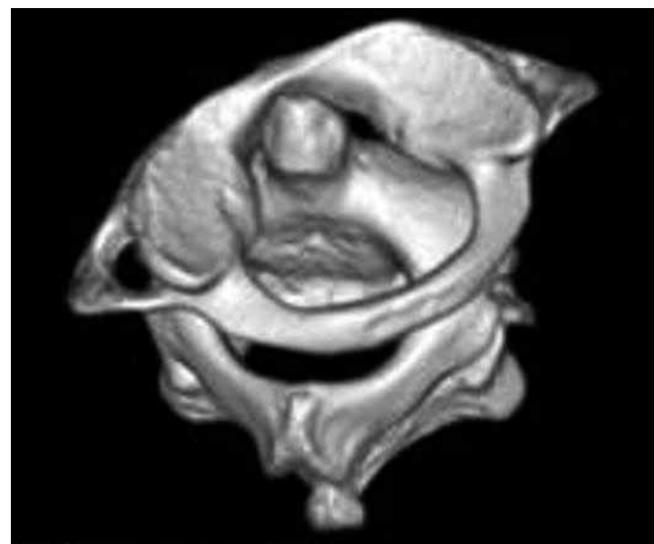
Three-dimensional reconstruction CT scan showing rotatory atlanto-axial subluxation.
